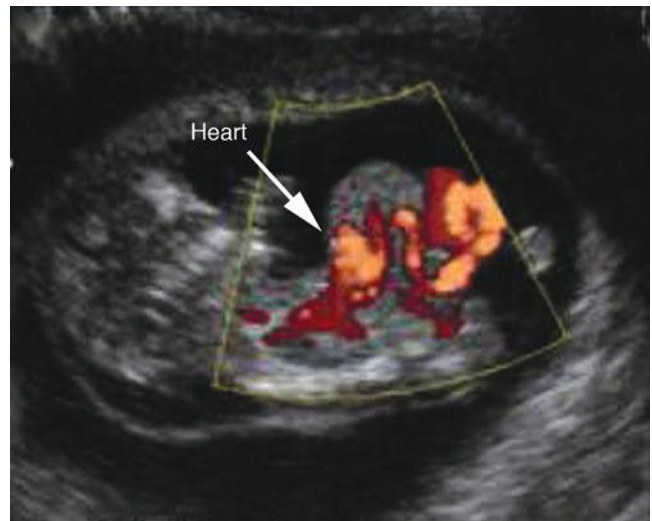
Color Doppler sonogram in the same patient with pentalogy of Cantrell. (Courtesy of Fernando Maia, 2005. Available at thefetus.net.)
